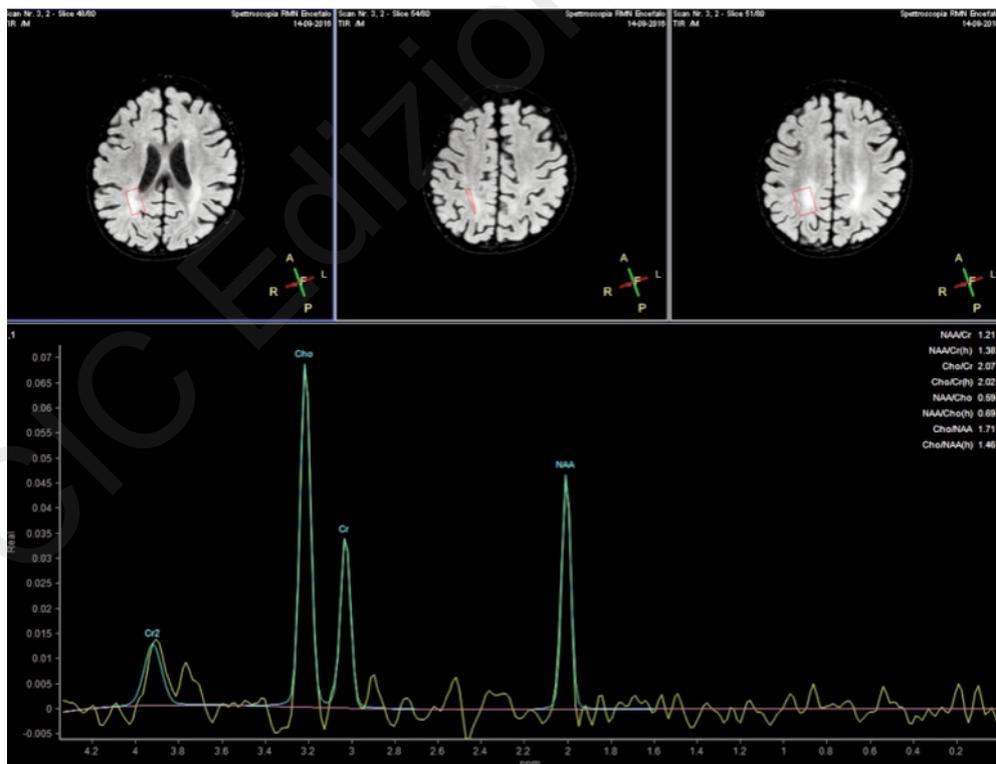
SPECT-MRI: Brain magnetic resonance imaging (MRI) conducted during admission in our Unit after 20 days old Dexamethasone treatment. It showed delayed myelination and mild cerebral atrophy (may be caused by the corticosteroid therapy).
